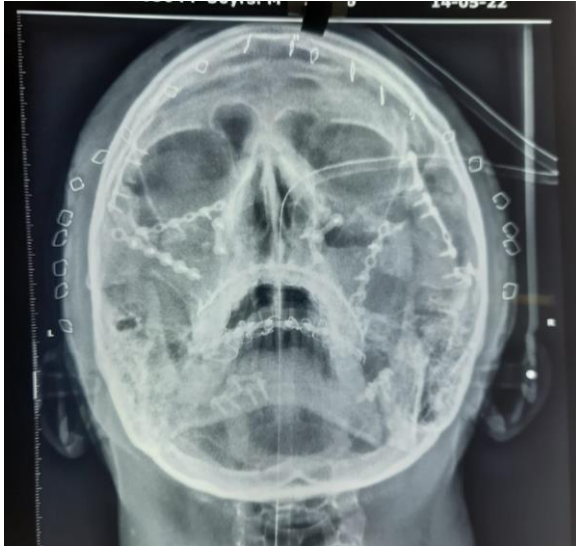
3D dimensional CT scan view.
